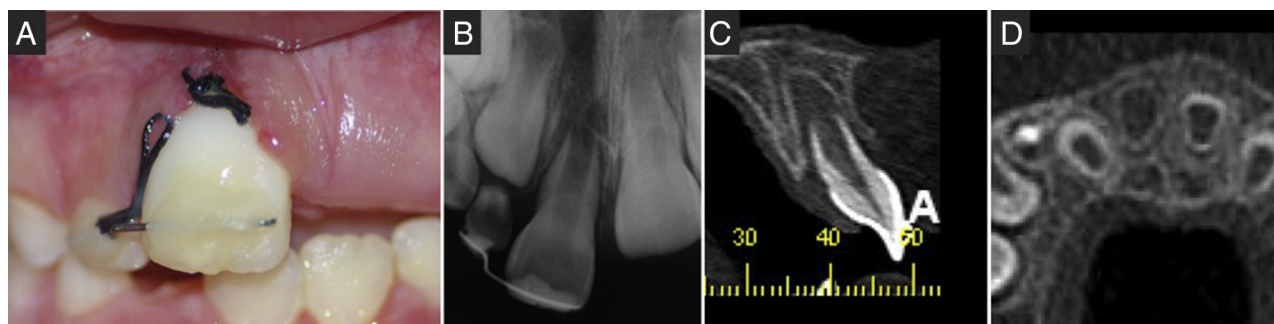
Initial appearance of the maxillary right central incisor showing clear malpositioning after replantation: (A) intraoral appearance; (B) baseline radiographs; and CBCT scans, (C) transverse and (D) axial views.
